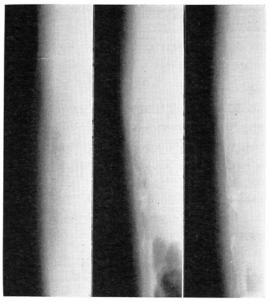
Case I. (A) Normal preoperative lateral roentgenogram of May 1965. (B) Calcified density with bony trabeculae in scar on lateral roentgenogram of June 1967. (C) No interval change on lateral roentgenogram 6 years later in July 1973.
